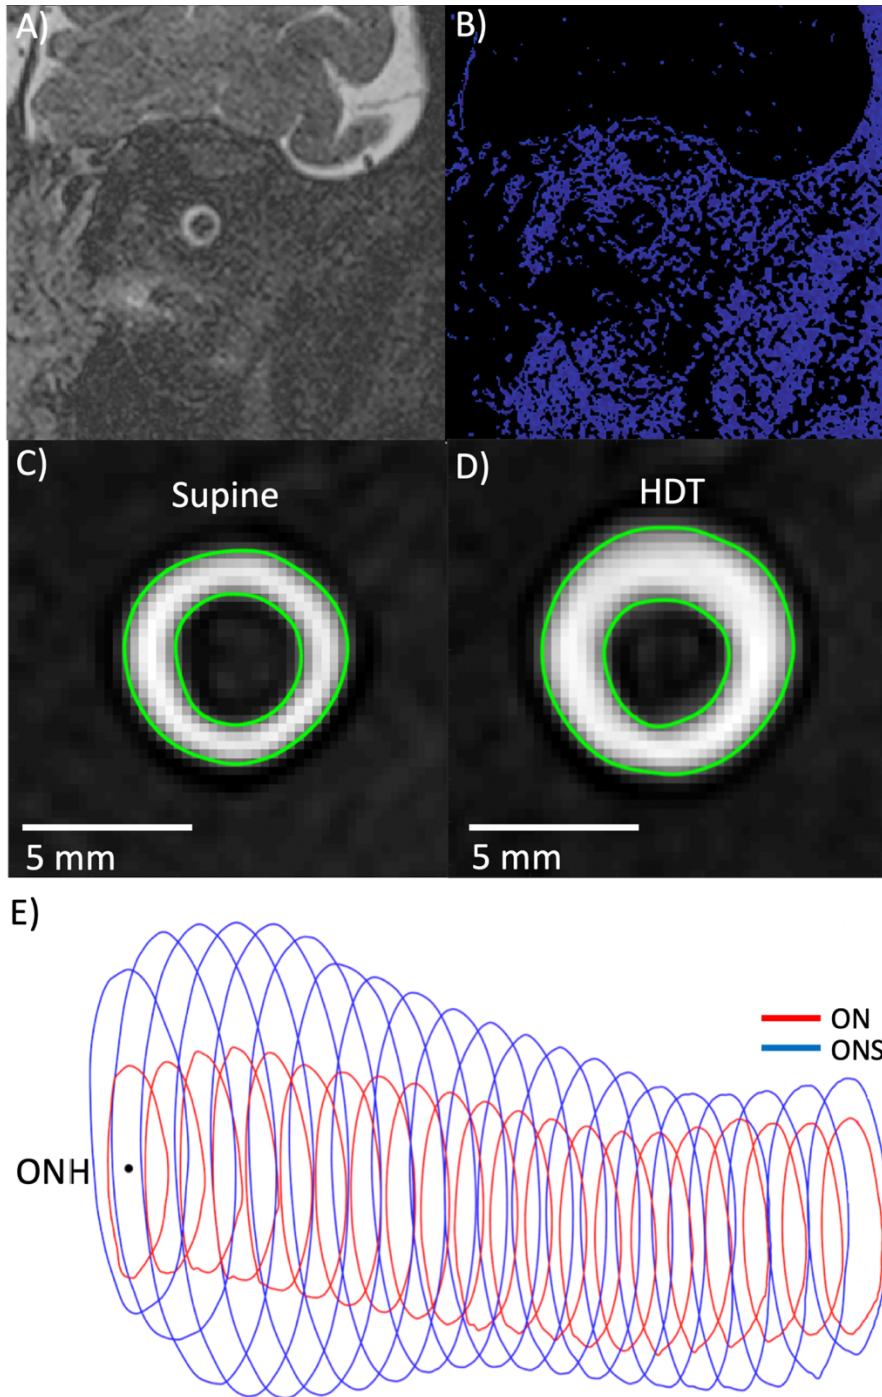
Methods for analysis of ON and ONS areas showing A) example coronal MRI before and B) after mask is applied based on histogram analysis of peak intensity values. C) Supine and D) HDT contours resulting from largest ONS area change at 3 mm location posterior to ONH (subject 16R). E) 3D representation of ON/ONS trajectory starting at the ONH showing contours at each slice of MRI volumetric data (subject 16R). Additional ONS slices that were generated using the ONS extension method are shown.
